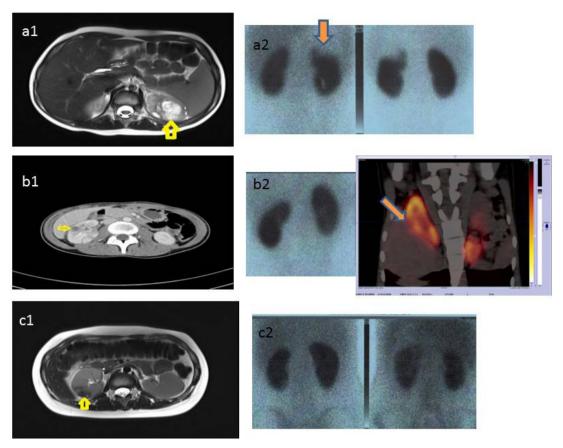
Renal abscess formation of the three cases (arrows). a, c. Abdominal magnetic resonance and DMSA scans of case 1 and 3 respectively b. Computed tomography, DMSA and coronal SPECT CT scans of case 2.
